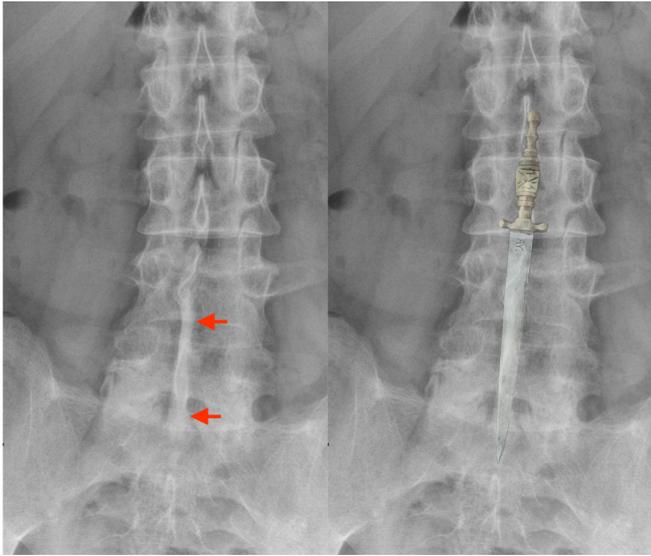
On the left, a frontal X-ray of the lower lumbar spine displays dagger sign (red arrows). On the right, a dagger is overlaid on the image to accentuate the finding.
